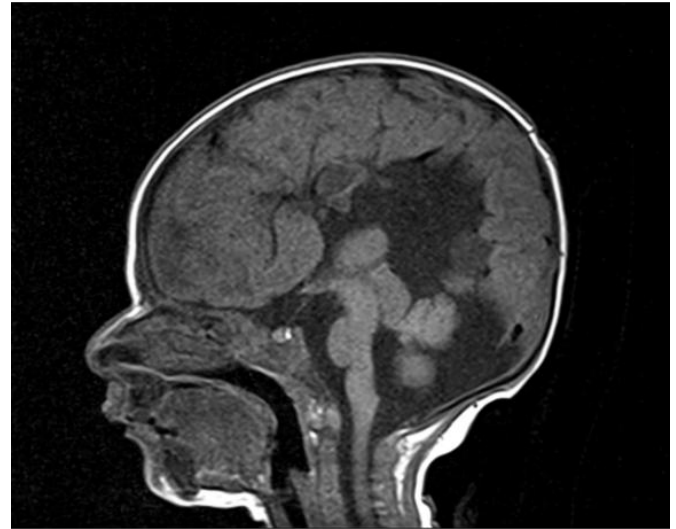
Brain MRI. T1-weighted image shows lo agenesis of corpus callosum and a multiseptated interhemispheric cyst.
